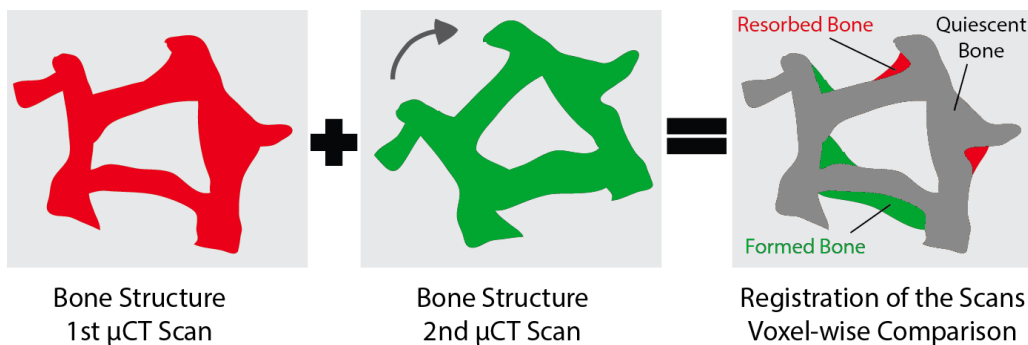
Principle of the μ CT based dynamic histomorphometry.
